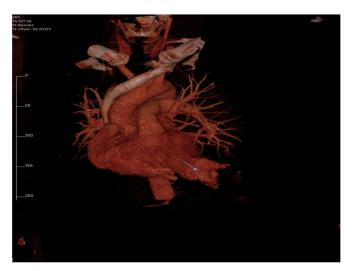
Three-dimensional view of left ventrilular pseudoaneurysm on three-dimensional thoracic computed tomography
